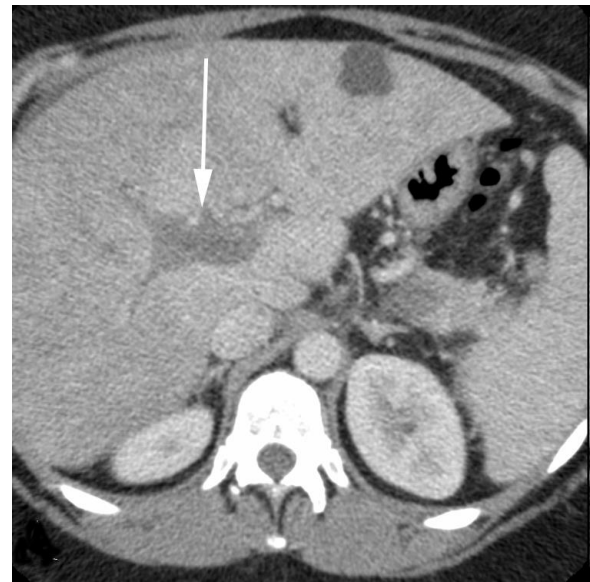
Portal venous thrombosis in a 34 year old woman on oral contraceptives with abdominal pain. Axial contrast-enhanced abdominal CT study during the portal venous phase study shows a clot filling the portal vein (arrow).
